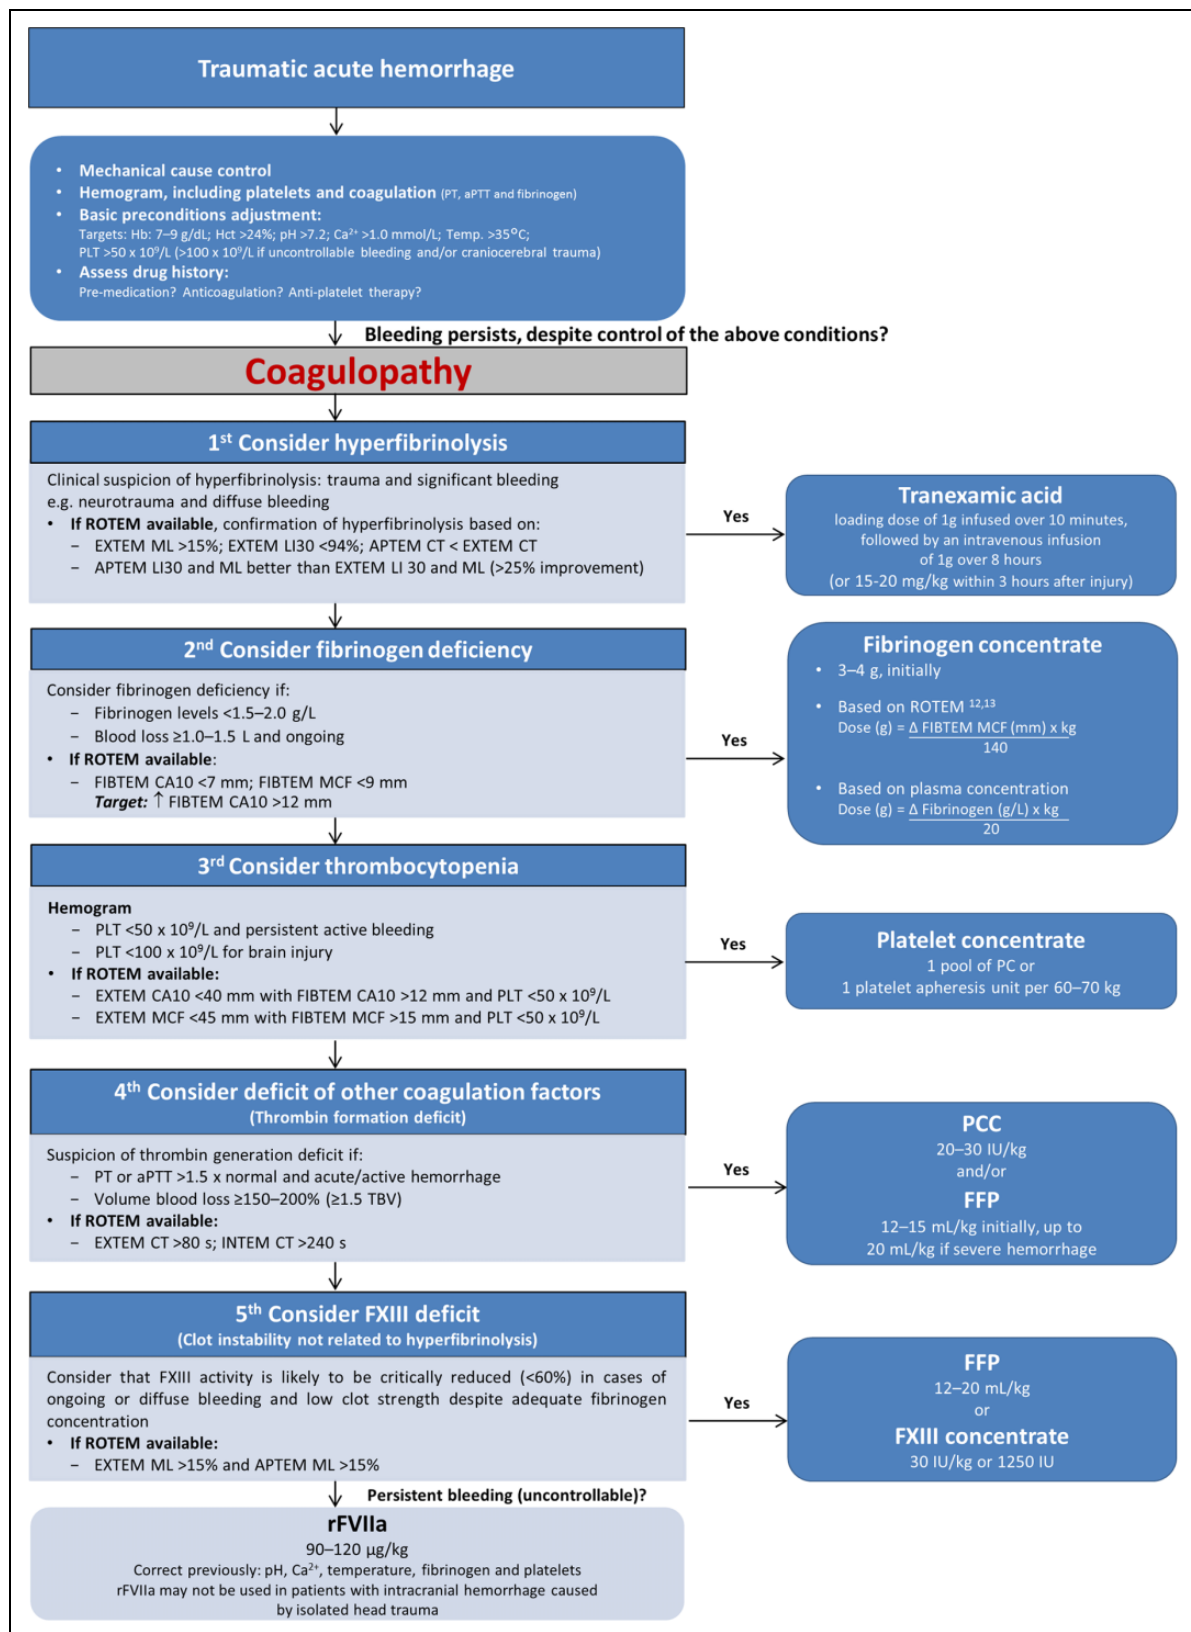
Proposed algorithm for the management of traumatic acute hemorrhage. aPTT indicates activated partial thromboplastin time; CA10, clot amplitude after 10 minutes; CFT, clot formation time; CT, clotting time; FFP, fresh frozen plasma; Hb, hemoglobin; Hct, hematocrit; LI30, lysis index after 30 minutes; MCF, maximum clot firmness; ML, maximum lysis; PC, platelet concentrate; PCC, prothrombin complex concentrate; PLT, platelet count; PT, prothrombin time; TBV, total blood volume.
